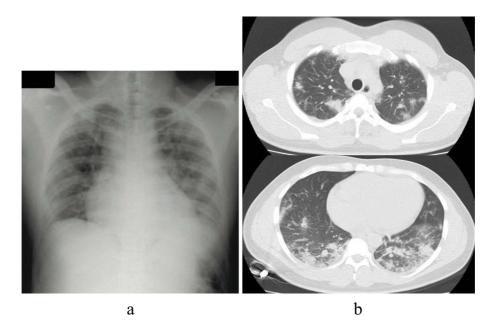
Chest X-ray and computed tomography images of the patient upon admission. Chest X-ray showing cardiomegaly, multiple nodular shadows in both lungs and an obscured left costophrenic angle (a). Chest CT image showing multiple nodular shadows primarily right under the pleura of both upper lobes in addition to infiltration of both lower lobes (b).
